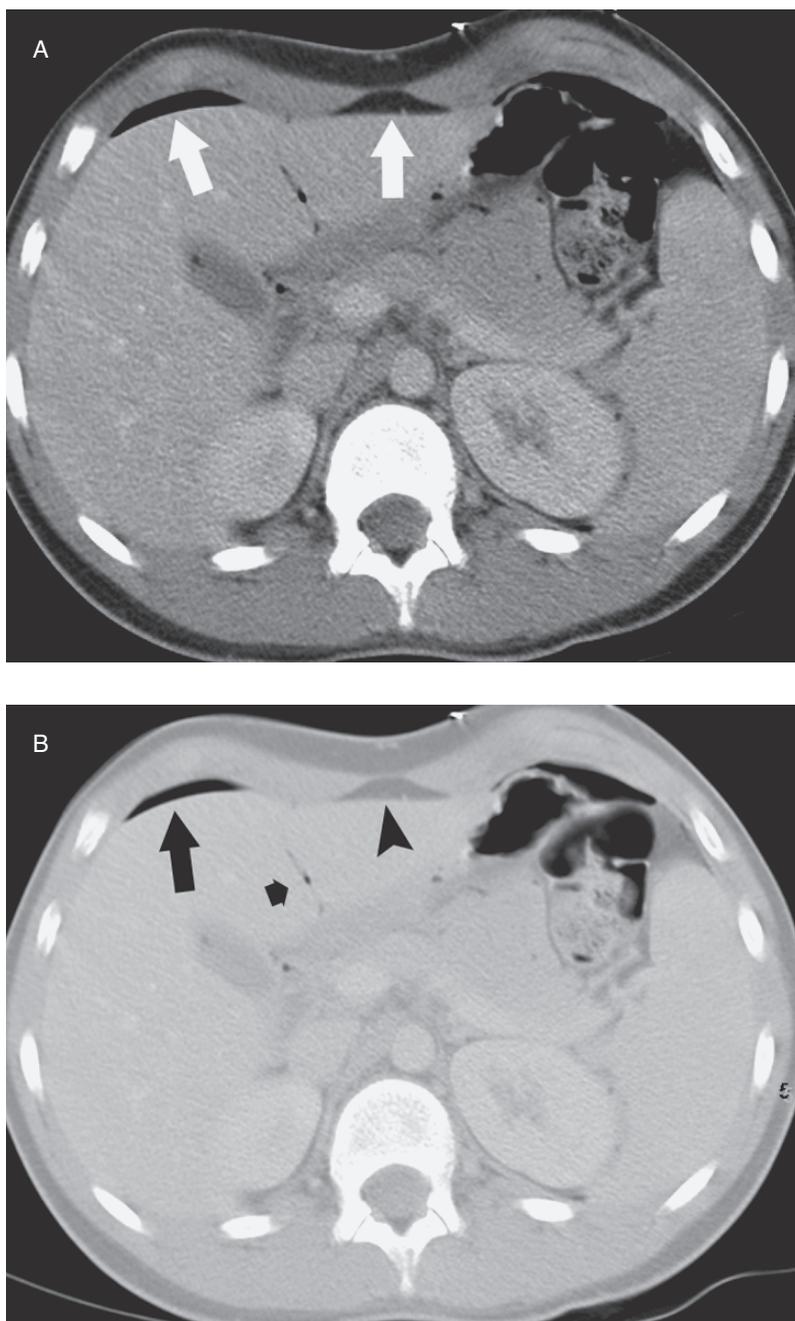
Pneumoperitoneum. (A) Axial CT image of the upper abdomen viewed in abdominal window demonstrating poor discrimination between free air (left arrow) and fat (right arrow) densities. (B) Same image viewed in lung window shows better discrimination between air (arrow) and fat (arrowhead) density. Small bubble of gas is also noted along falciform ligament (short arrow).
